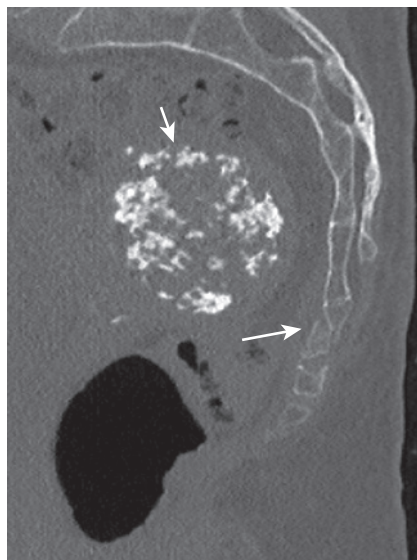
Sagittal computed tomography of the sacrum and coccyx shows a minimally displaced fracture of the coccyx (long arrow). A calcified uterine fibroid is incidentally noted (short arrow).
